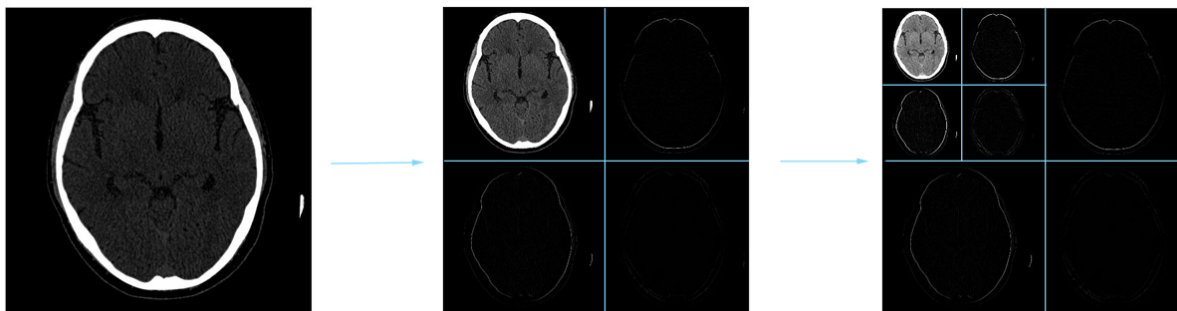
2-level wavelet decomposition. (Brain CT image: MIIRC@M)
